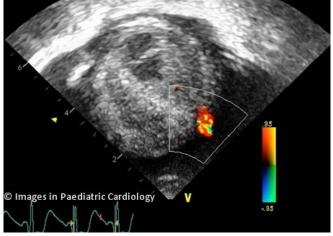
Colour Doppler signal along the myocardial defect demonstrating the connection betwee<u>n the intraventricular cavity and the pericardial</u> space.
